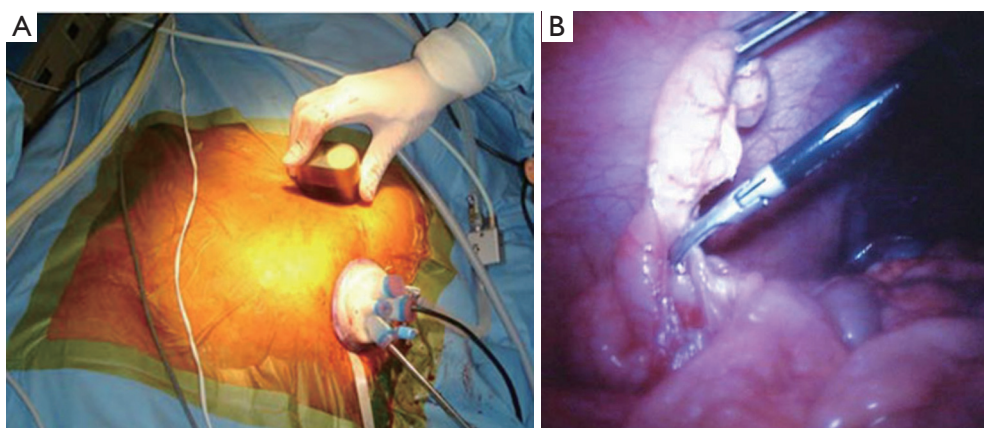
(A) Deployment of magnet on anterior abdominal wall during nephrectomy (13); (B) internal MAGS camera view of appendix with internal LED illumination and ultrasonic shears dividing the appendiceal mesentery (13). MAGS, magnetic anchoring and guidance system; LED, light emitting diode.
